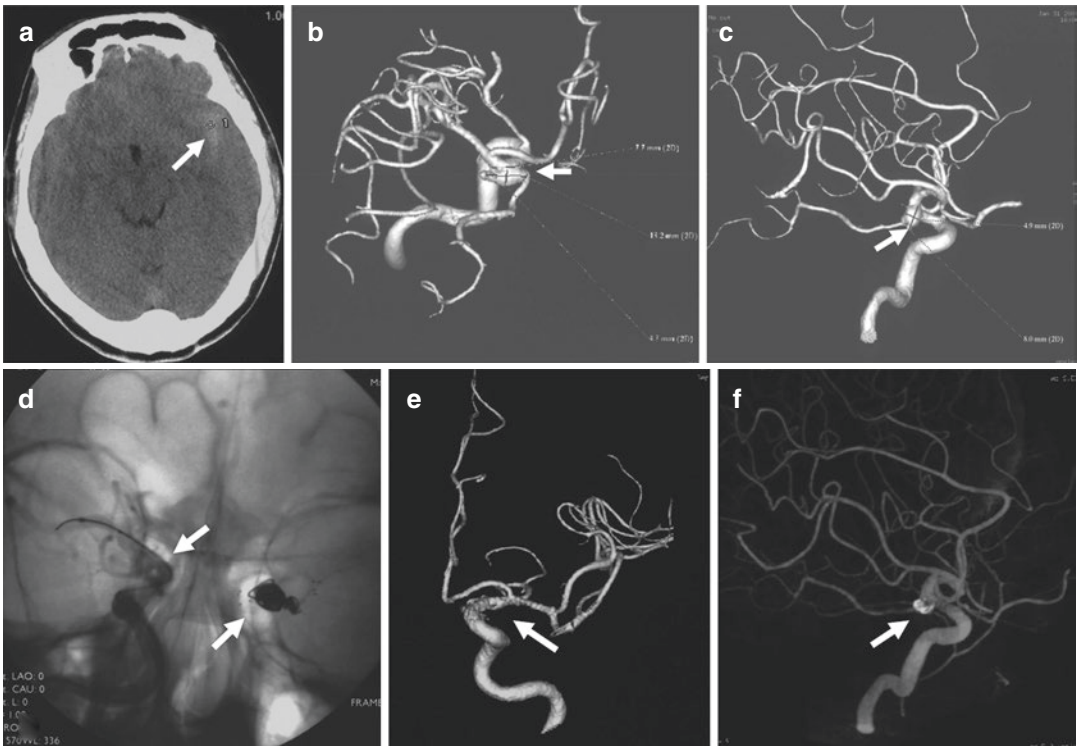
A 62-year-old man presented with a ruptured posterior communicating artery aneurysm. (a) CT scanning showing subarachnoid hemorrhage of the left Sylvian fissure. (b) 3-D reconstruction of the left internal carotid artery injection showing a 13 mm × 5 mm posterior communicating artery aneurysm (arrow). (c) 3-D reconstruction of the right internal carotid artery injection showing a 5 mm × 8 mm posterior communicating artery aneurysm (arrow). (d) Frontal view of the unsubtracted image showing bilateral aneurysms were all treated with Neuroform stent-assisted coiling (arrows). (e) 3-D reconstruction of the left internal carotid artery injection after treatment showing the disappearance of the aneurysm (arrow). (f) 3-D reconstruction of the right internal carotid artery injection after treatment showing the coil mass in the aneurysm (arrow)
